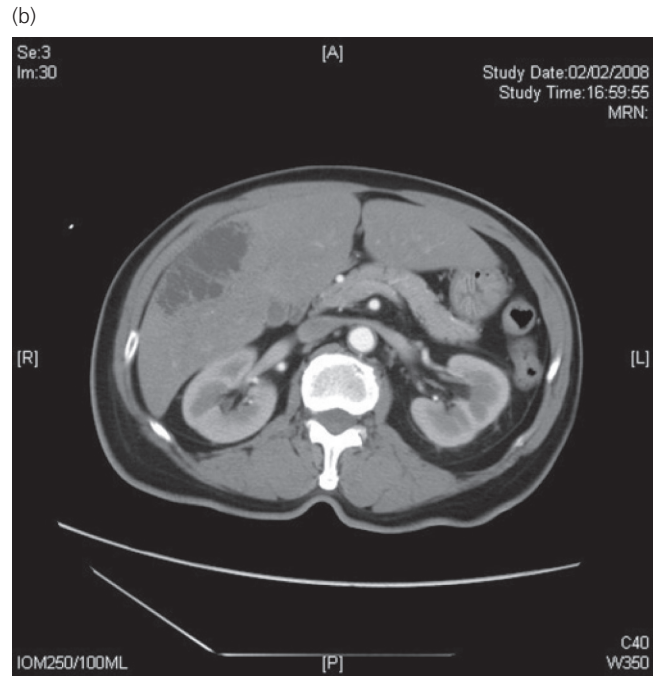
(a) CT-scan of an 82-year-old man with fever and newly diagnosed diabetes. Blood culture grew *Klebsiella pneumoniae*. The scan shows an 8 × 8.2 cm heterogeneous lesion in the right lobe of the liver composed of multiple rim-enhancing lesions, with septation and hypodense cystic components. A further three smaller similar lesions (1–2.5 cm) were also seen inferiorly. Overall features are suggestive of liver abscesses. He recovered with drainage and antibiotics. (b) CT-scan of a 77-year-old woman with underlying diabetes, fever and right upper quadrant pain. Both blood culture and pus (from the liver abscess) grew *K.*
